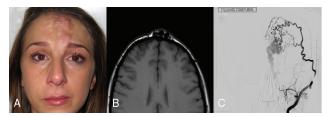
(A) AVM of the forehead. The AVM involves skin, subcutaneous tissue and muscle: this makes this AVM an S2. (B) Axial MRI of the same patient involving the forehead in its full thickness but sparing the bone. This, again makes the AVM S2. (C) Angiography demonstrating multiple arterial feeders draining into one single vein (E2). AVM, arteriovenous malformations.
